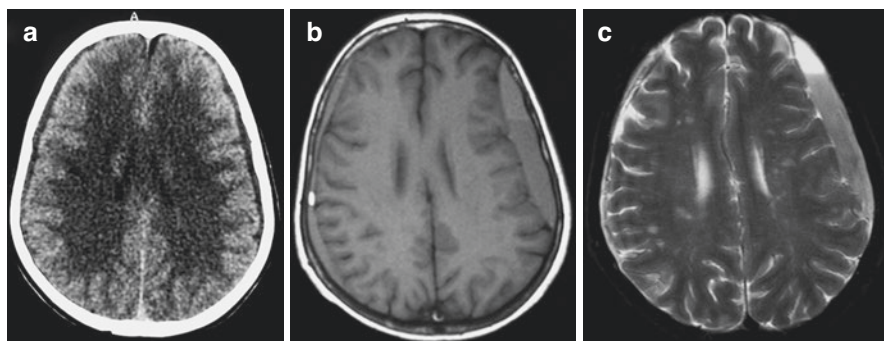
Case 3. Initial CT-scan in a 48-year-old woman after 2 days from trauma (a). There is a small bilateral subdural hygroma (a). Follow-up T1 (b) and T2-weighted MRI (c) images demonstrated newly developed chronic subdural hematoma on the left side
